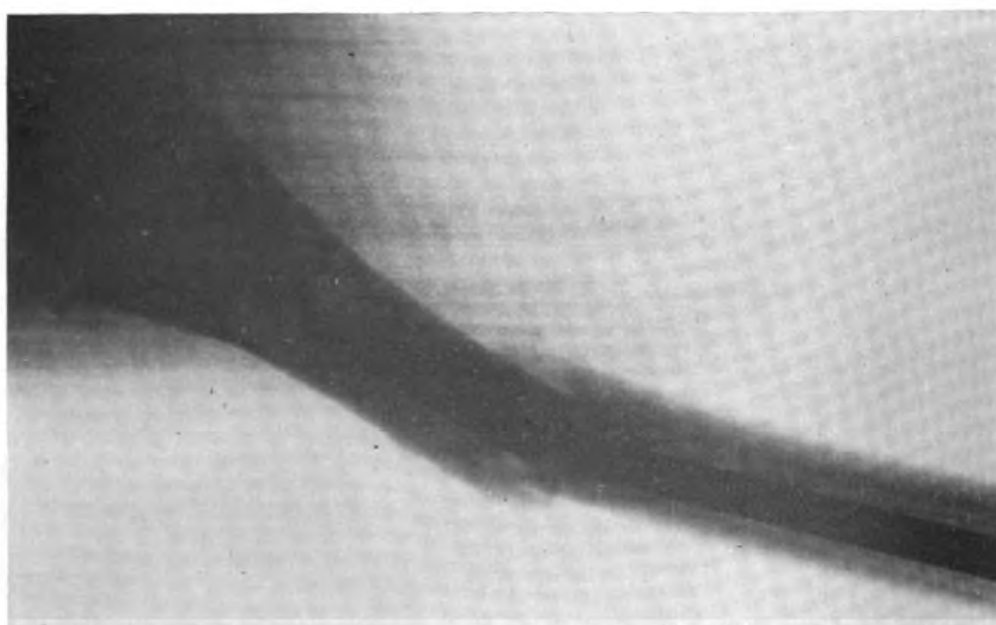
Case 3. Postoperative lateral x-ray at 4 weeks.
